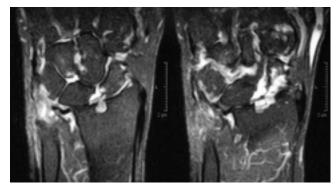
Magnetic resonance imaging scan (with gadolinium) of left wrist.
